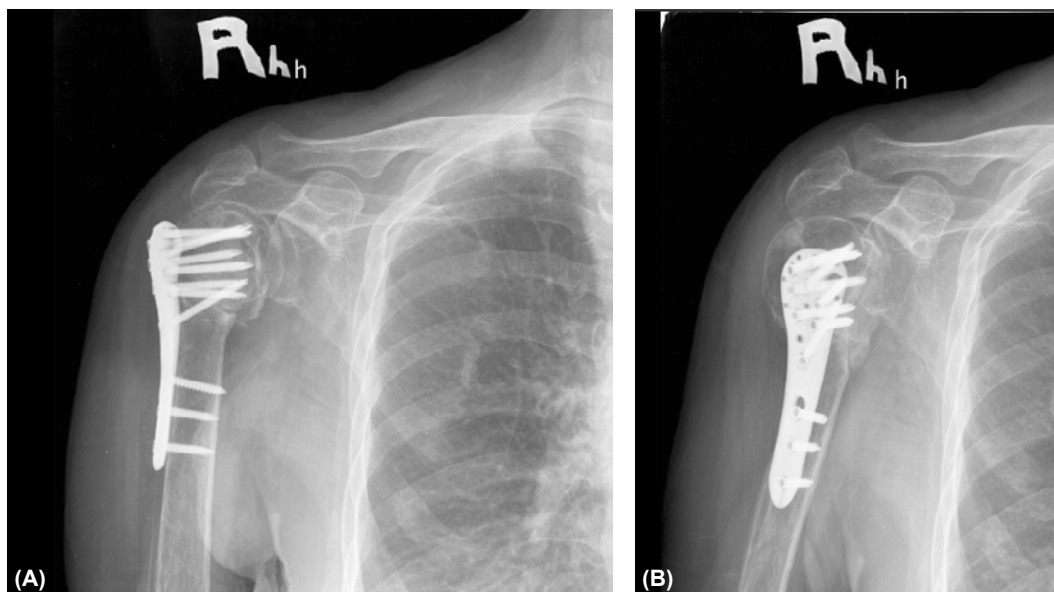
Two months post-operative radiographs showing good incorporation of allograft with head and shaft fragment and new bone formation. (A) Anteroposterior and (B) lateral view.
